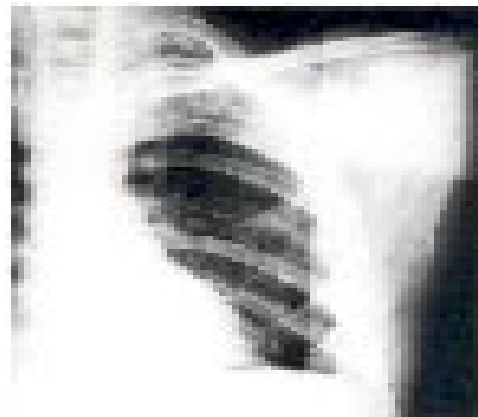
Chest roentgenogram PA view taken on presentation showing multiple left ribs destruction, blunting of left costophrenic angle, left pleural thickening and volume loss over left lung
